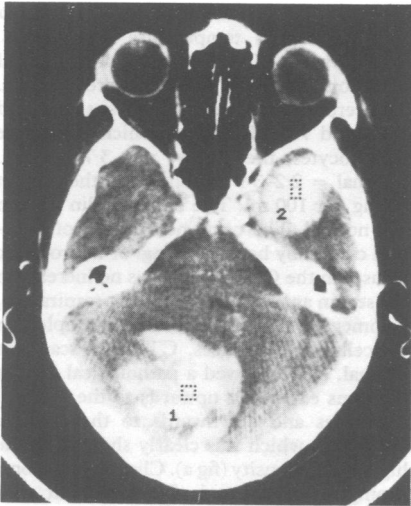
Figure CT scan showing right temporal lobe and left cerebellar hemisphere haemorrhages.
